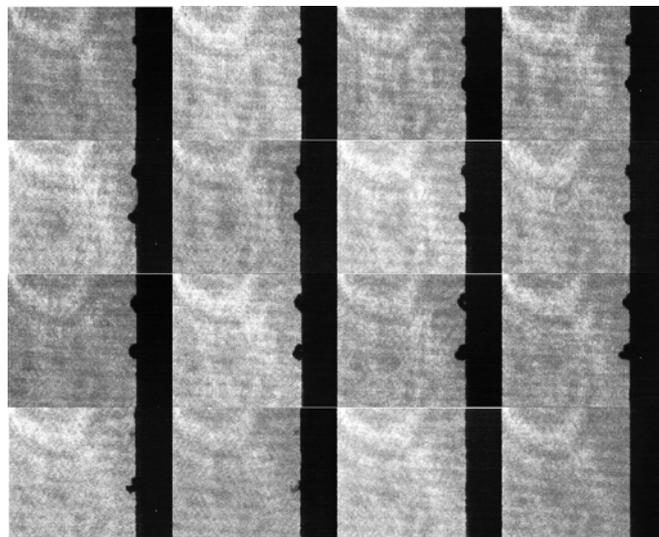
Photographic series of the interaction of three BR14 microbubble contrast agents with high-intensity focused ultrasound. Frame interval  $2 \mu\text{s}$ , frame size  $2.56 \text{ mm} \times 2.09 \text{ mm}$ .
